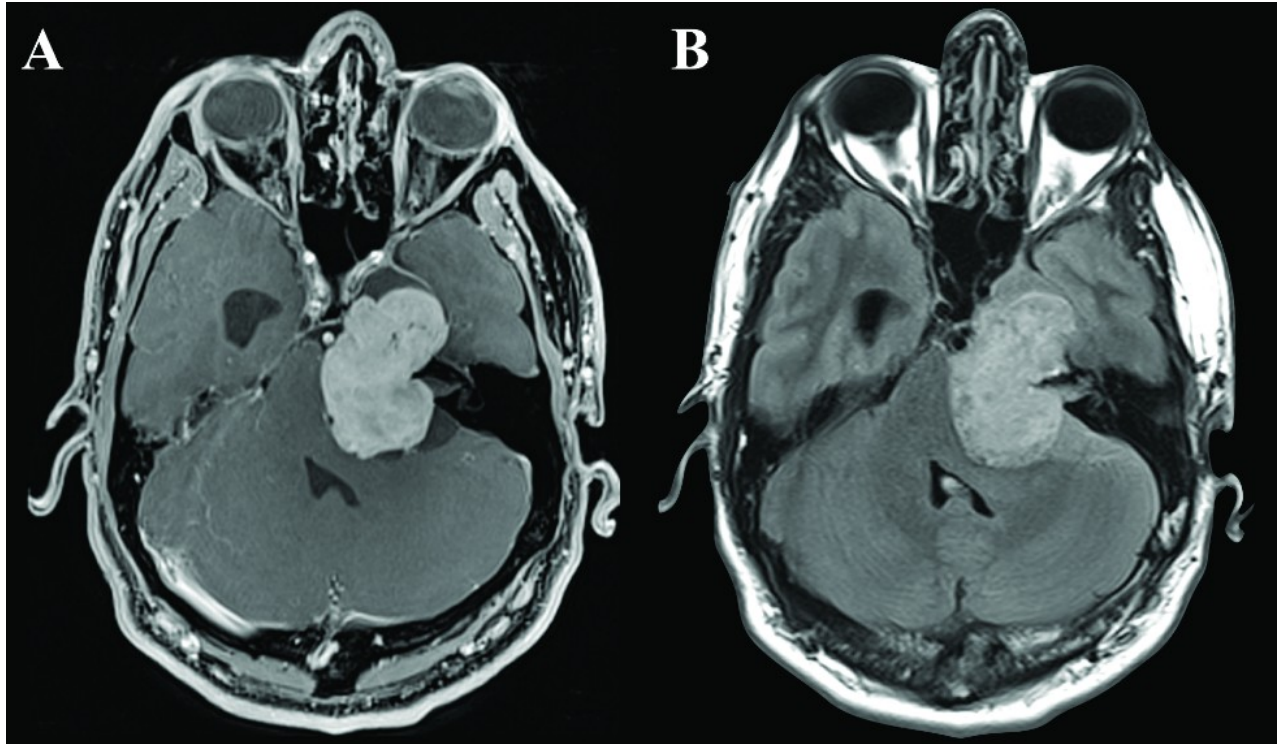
Trigeminal schwannoma: Magnetic resonance imaging (MRI) revealed a contrast-enhancing T1 hypo intense (A) and a fluid-attenuated inversion recovery (FLAIR) hyper intense (B) mass in the left middle and posterior fossa. [22]
